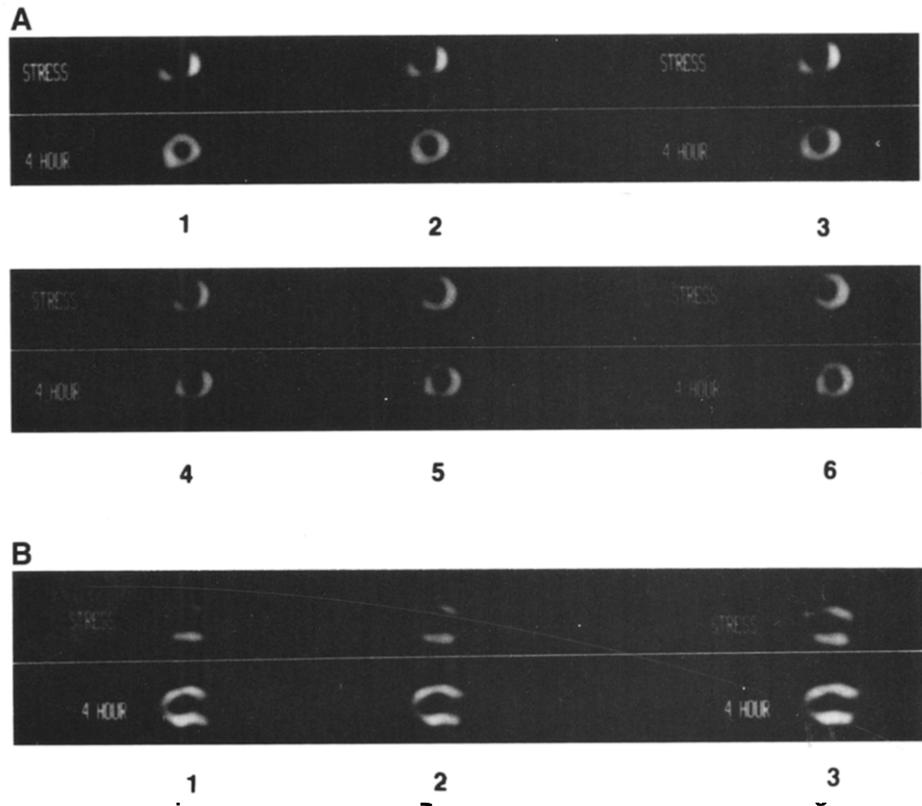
SPECT images during exercise and at 4 h after exercise demonstrating Ischemia accompanied by angina. A. Short-axis view. Reversible anteroseptal, inferoseptal and inferior defects at apical and midventricular levels with partial septal reversibility at the base; reversible anterior defect at the apex with partial reversibility at midventricular and basilar levels (segments 1 to 6 progress from apex to base). B. Vertical long-axis view. Partially reversible anteroapical and inferoapical defects (segments 1 to 3 progress from septal to lateral surfaces). Coronary arteriography demonstrated 90% stenosis of the proximal left anterior descending artery.
